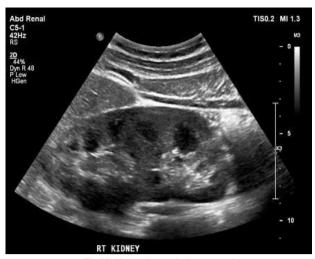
Normal renal ultrasound
